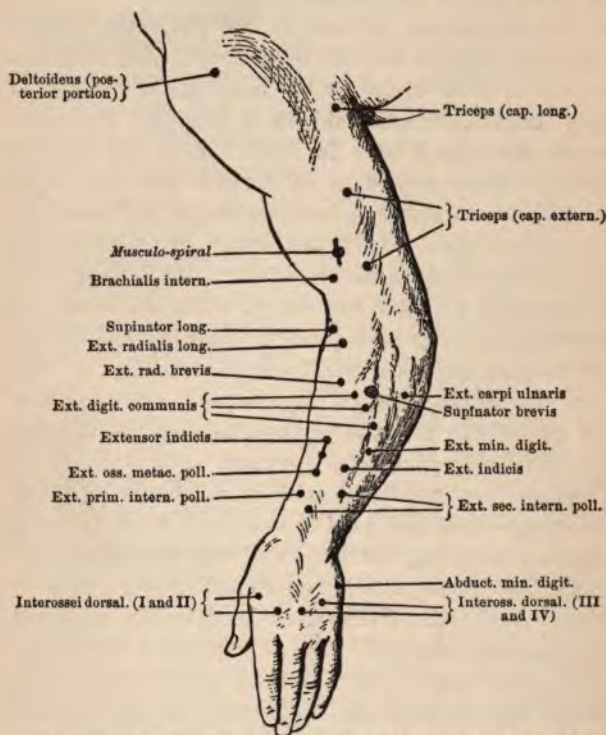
MOTOR POINTS OF DORSAL ASPECT OF LEFT ARM.
